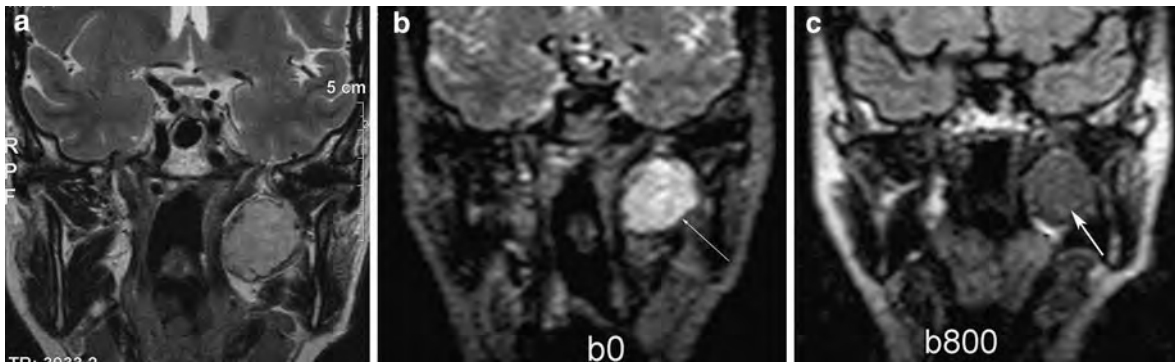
Pleomorphic adenoma of the deep lobe of the right parotid gland, appearing hyperintense on T2-weighted images (a), hyperintense on a diffusion-weighted image with b factor of 0 s/mm² (arrow, b) and hypointense with b factor of 800 s/mm² (arrow, c); the ADC value is >1.2
